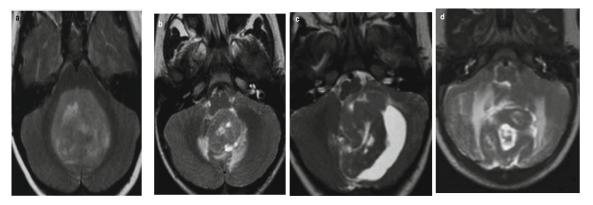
Variability of signal intensity on T2-weighted images:
